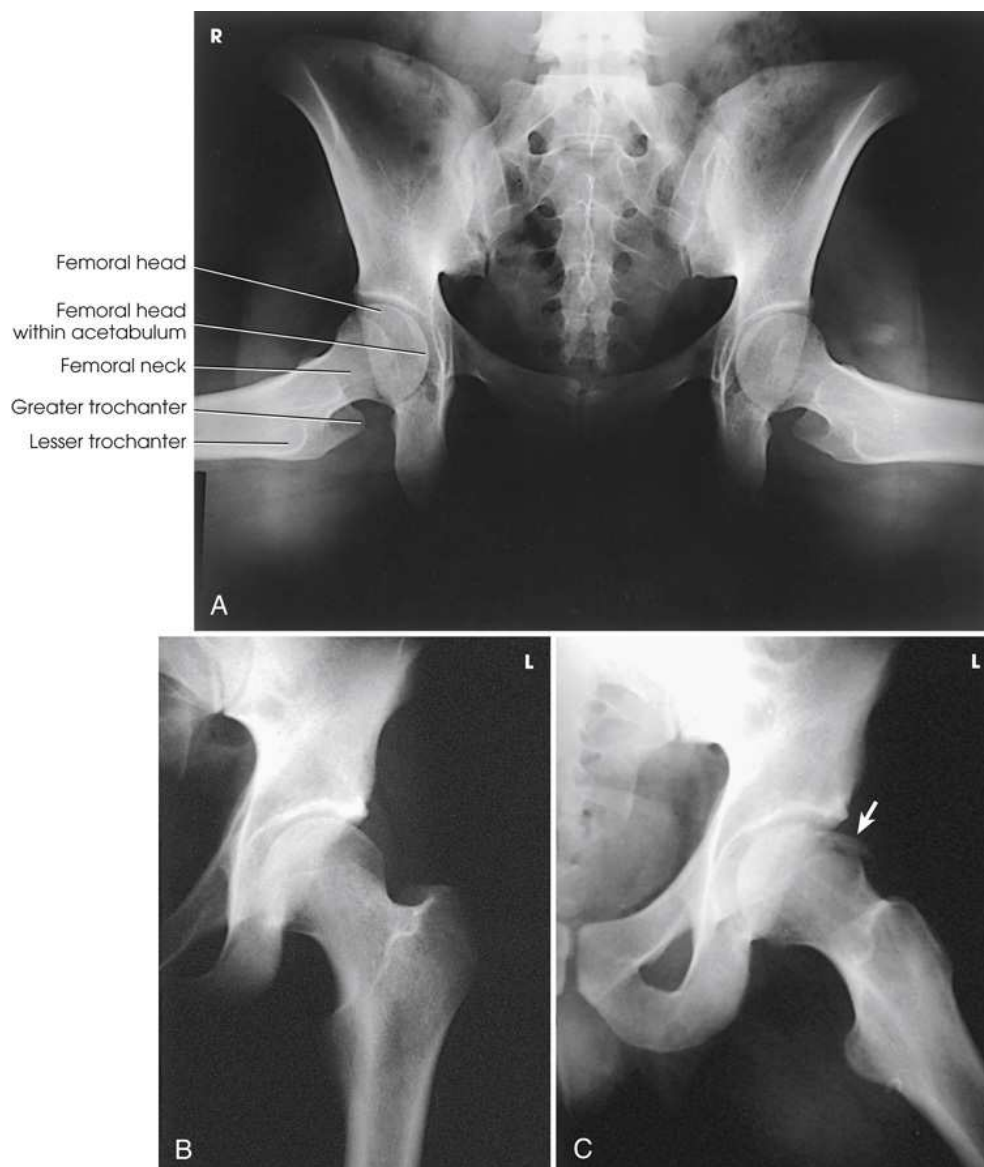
Axialateral femoral necks: Cleaves method. (A) Bilateral examination. (B and C) Unilateral hip examination of a patient who fell. No fractures were seen on initial AP hip radiograph (B), and a second projection using the Cleaves method was performed. Chip fracture of femoral head (*arrow*) was seen (C). At least two projections are required in trauma diagnoses.
